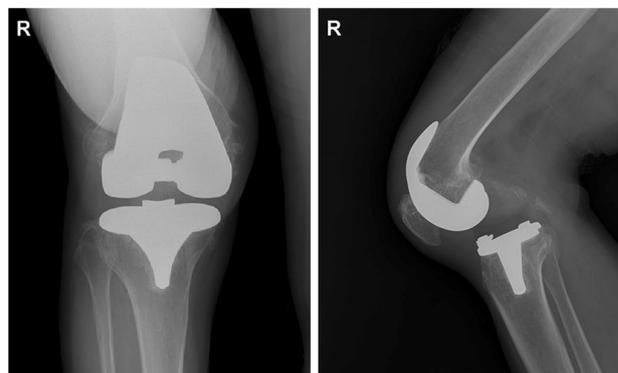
AP and lateral radiograph right knee showing dislocation of the TKA
